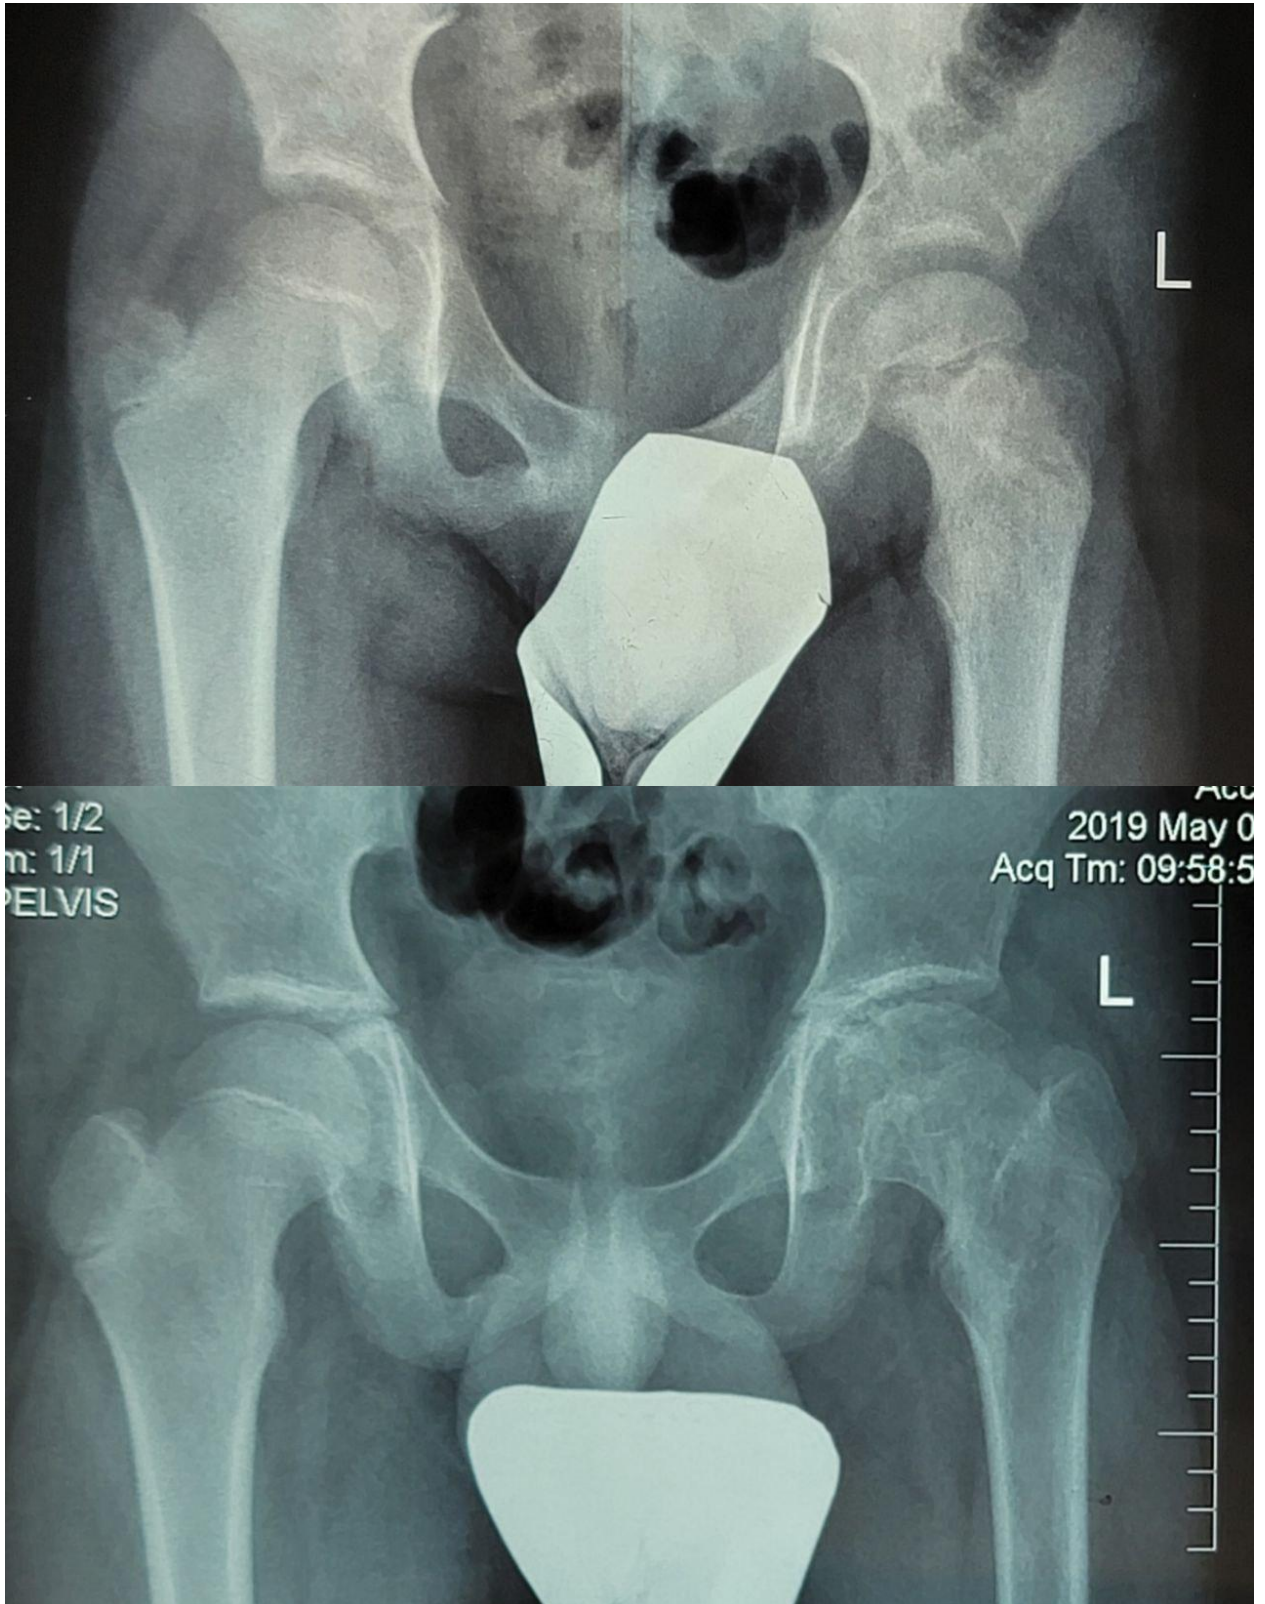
X-ray of a child with septic arthritis of the hip joint. Osteolysis is visible in the area of the growth zone. The X-ray taken a 2 years later shows a partial closure of the growth zone and a relative shortening of the left femoral neck.
